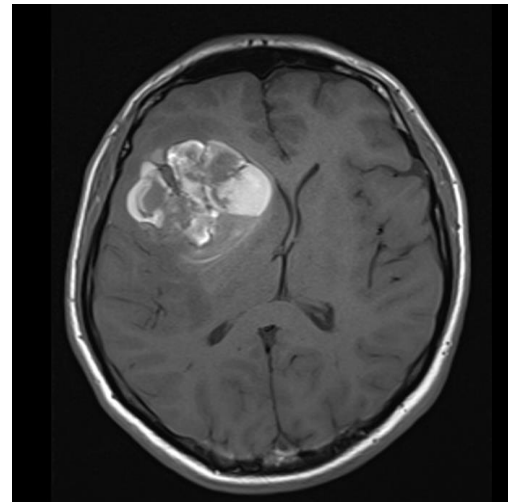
Brain MRI: On the axial T1-weighted image, a hemorrhagic mass of approximately 60x53 mm in the right frontal lobe with minimal white matter edema around it and hemorrhagic fluid-fluid levels is observed. Slight left shift in the midline and subfalcian herniation are observed secondary to the mass effect. There is compression in the right basal ganglia and right thalamus.
